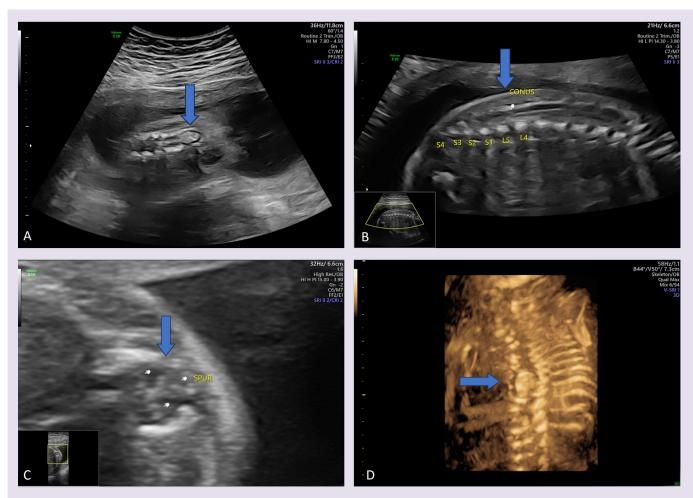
Ultrasound scan revealed a midline bony septum in the dorsal spine (A and D) which was suggestive of diastematomyelia. Splitting of the dorsal cord was also seen (C) along with low lying conus featuring tethered cord (B). No intracranial abnormality was seen. There was no associated other anomaly. Imaging features were suggestive of Diastematomyelia.
